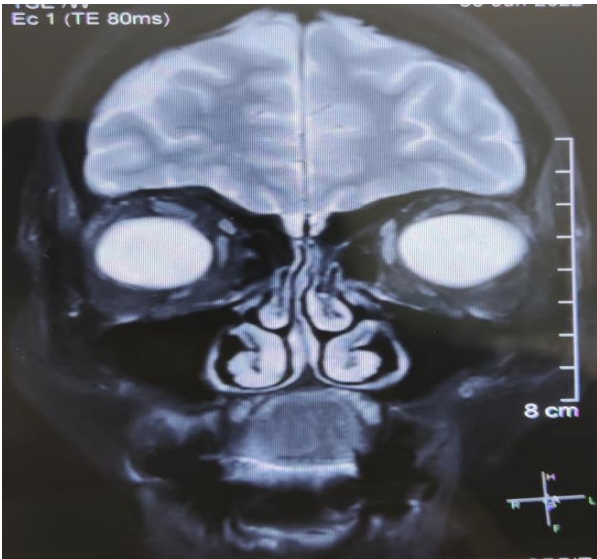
Case 2 MRI showed inferior displaced IR and nasal shift of SR.
